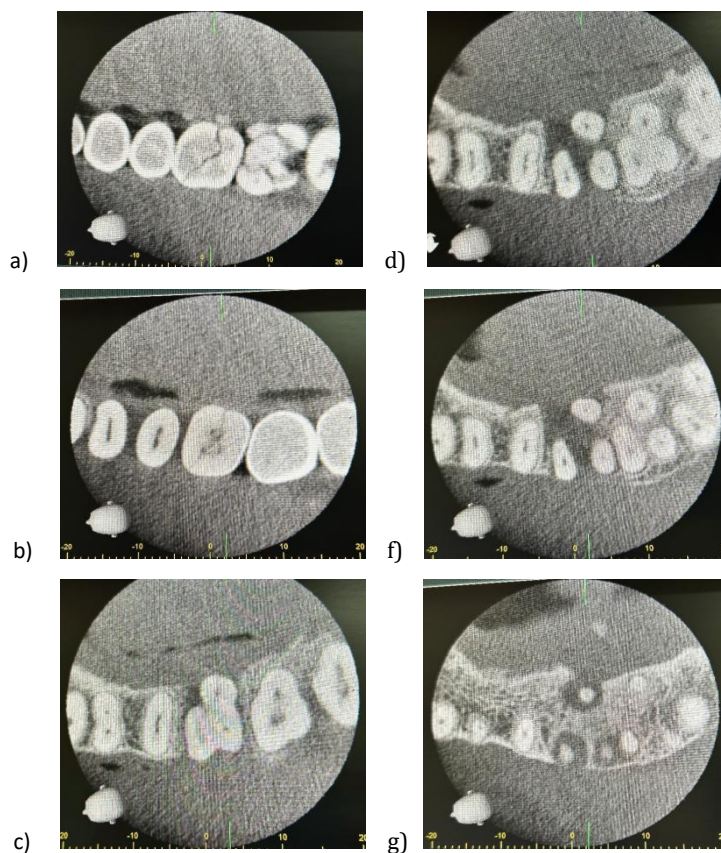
(a-g): CBCT images of the AXIAL SECTIONS showing the extent of the crack and the periapical lesion surrounding the tooth
